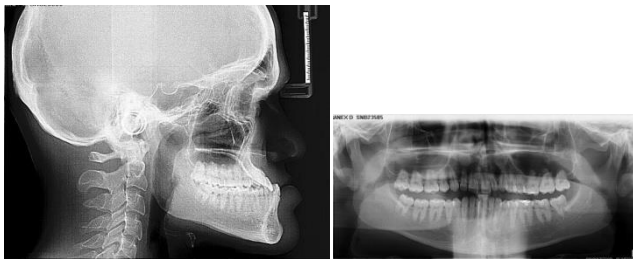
a Pre-Treatment Lateral cephalogram and 15 b- Pre-treatment Orthopantomogram
